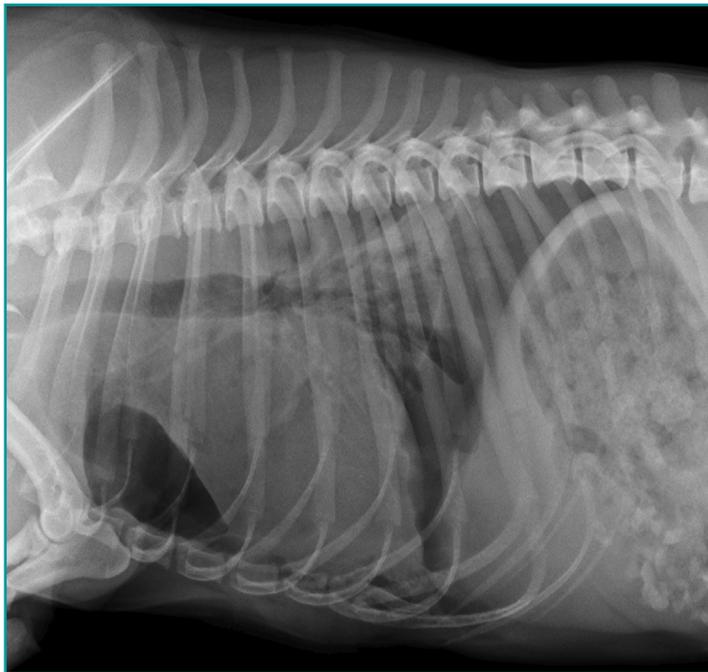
Post-operative chest X-ray (case number 5), latero-lateral view in right decubitus; no signs of pneumothorax are present.
